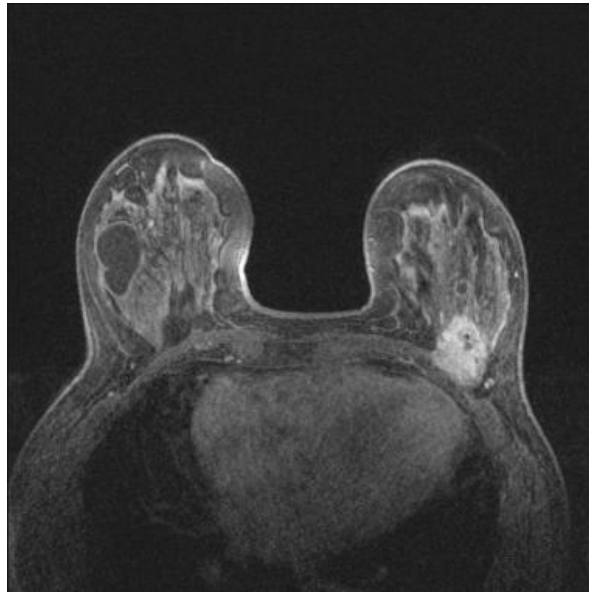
Same patient as in previous image: T1-weighted image with fat suppression after contrast clearly shows the posterior cancer invading the pectoralis major on the left.
